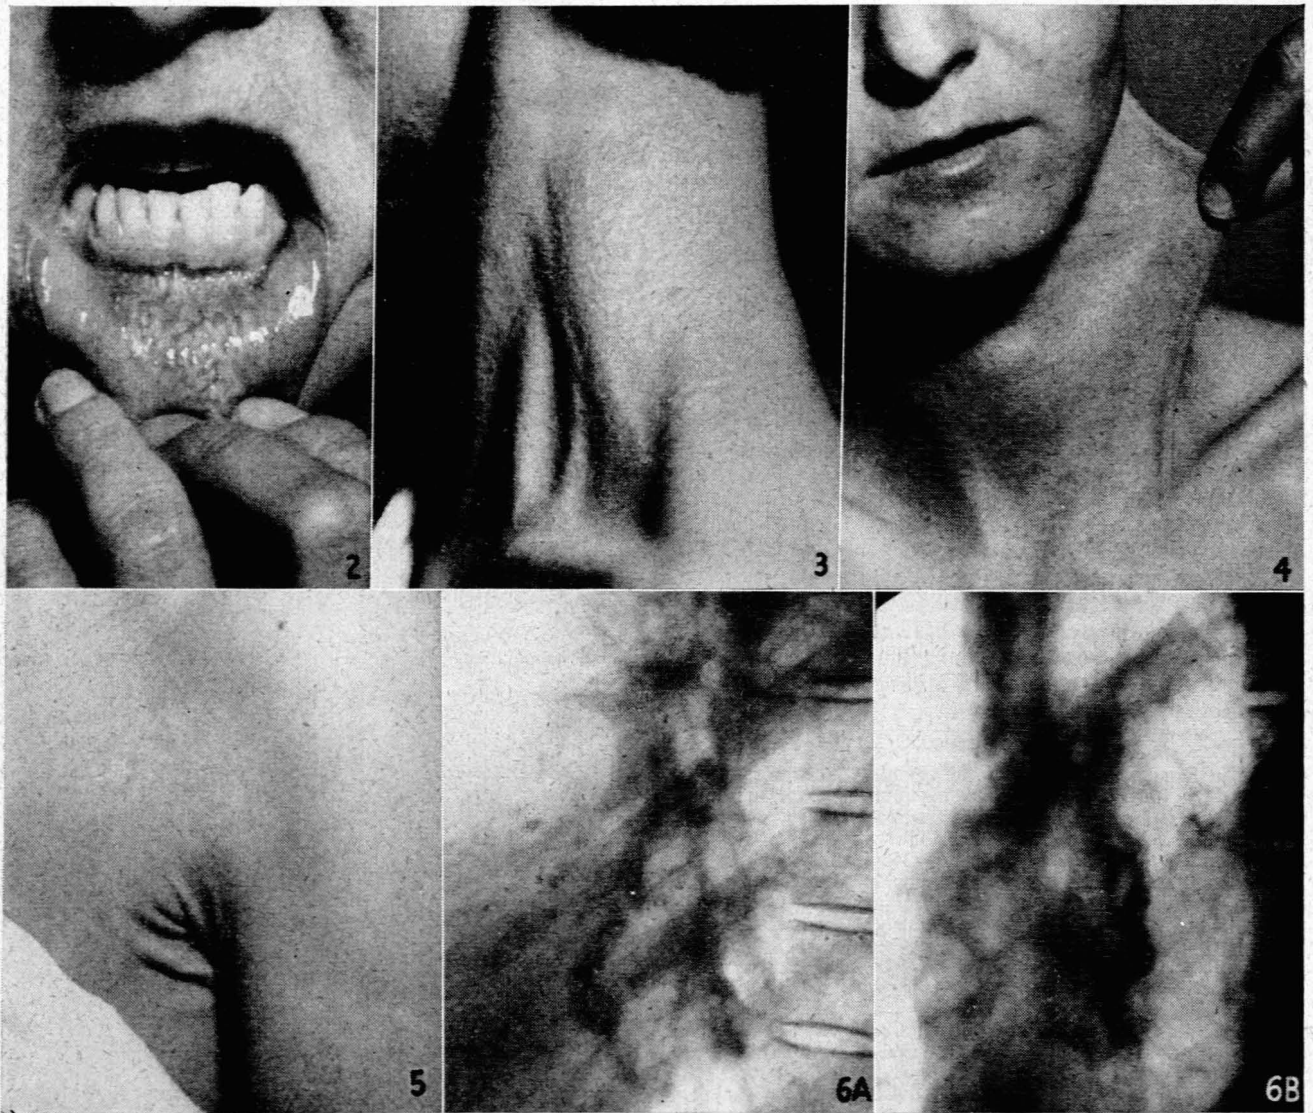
Buccal mucosa of lower lip, showing typical crepe-like lesion of pseudoxanthoma elasticum. Fig. 3. Left side of neck showing the typical lesion. Fig. 4. Abnormal laxity of skin of the affected area of neck. Fig. 5. Excessive folds of lax skin of left axilla. Fig. 6a & 6b. Left anterior oblique radiographs of heart showing calcification of posterior descending branch of right coronary artery, and possibly the circumflex branch of the left coronary artery.
